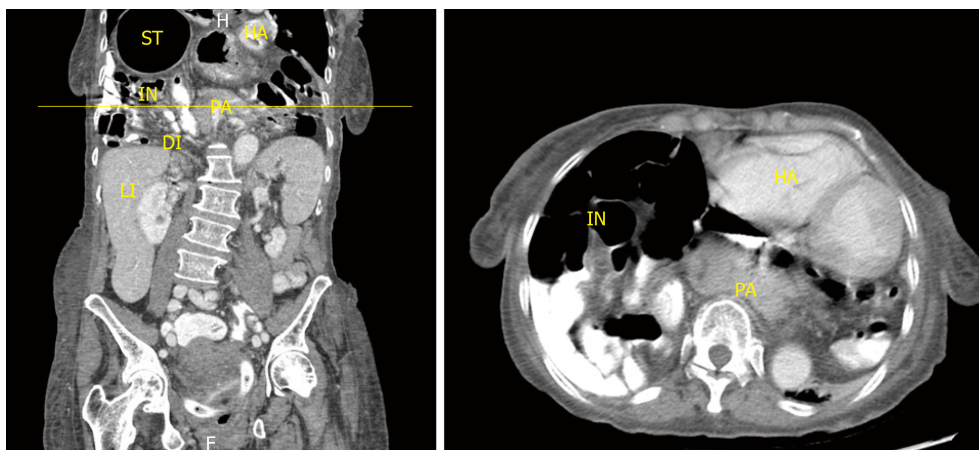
Demonstrate the contrast-enhanced computed tomography (oral and intravenous), coronal and axial reconstruction with large hiatal hernia with pancreas in the chest. ST: Stomach; IN: Small intestine; LI: Large intestine; PA: Pancreas; DI: Diaphragm; HA: Heart.
